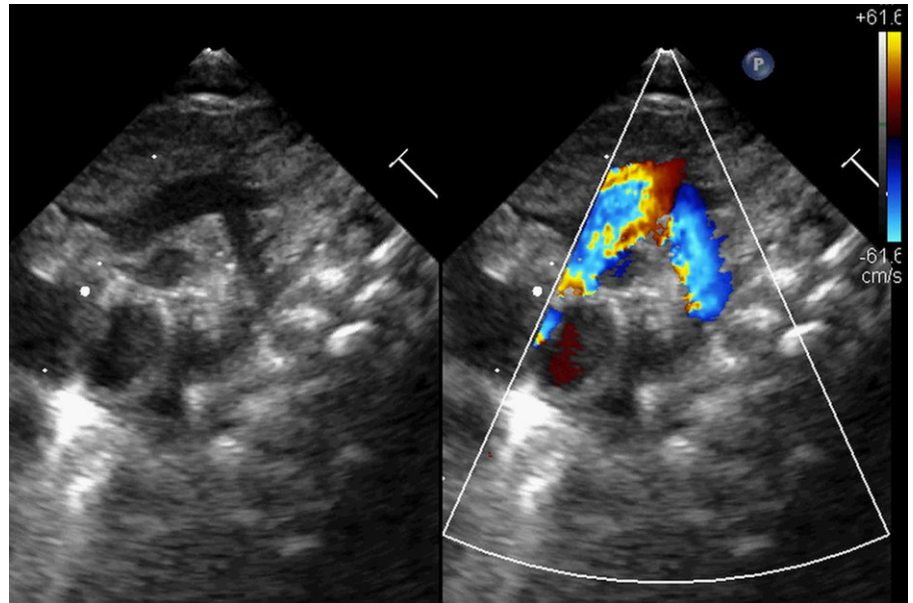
Movie 1: pre-procedural echocardiography showing critical aortic coarctation.
